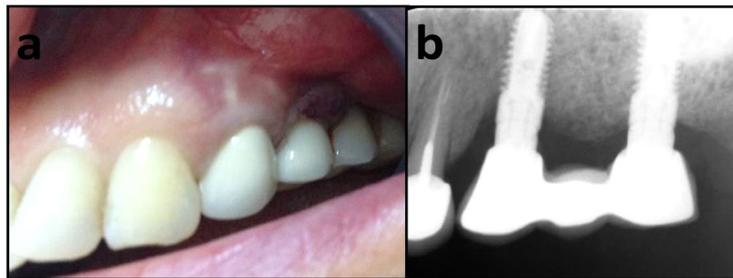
A. Intraoral view showing the exophytic red mass on the buccal aspect associated with the implant. B. Periapical radiograph of the lesion. Note the vertical crestal bone loss around the implant.
